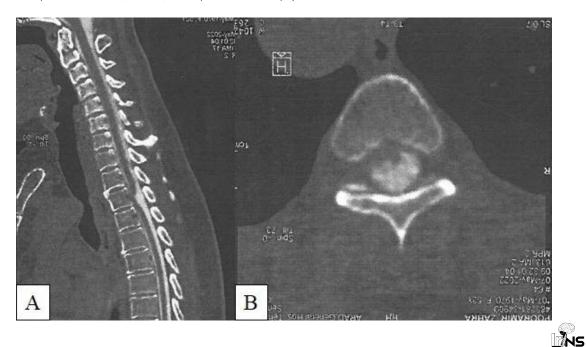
Pre-operative sagittal (A) and axial (B) thoracic CT myelography images utilized to exclude cord displacement caused by an arachnoid cyst, demonstrating free passage of dye posterior to the displaced spinal cord
